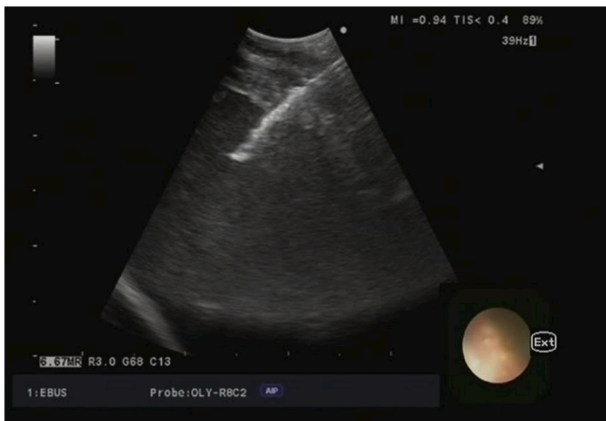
Transesophageal bronchoscopic ultrasound-guided fine needle aspiration of ascites fluid.
